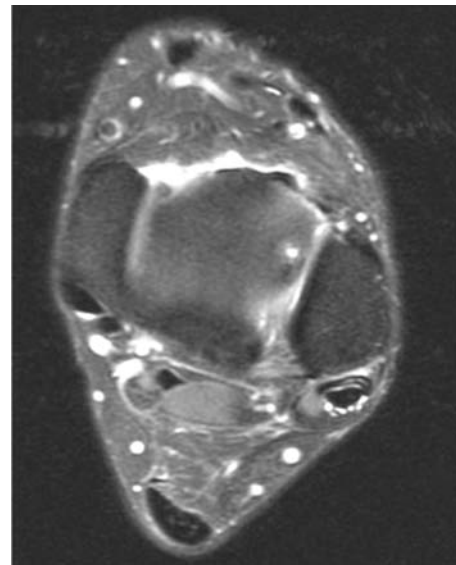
Peroneal brevis tear, T2-weighted image
